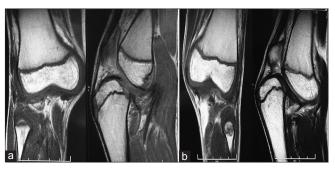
MR images T2WI (coronal and sagital views) (a) right knee joint (b) left knee joint showing small epiphysis, trumpet shaped metaphysis, attenuated ACL and PCL
